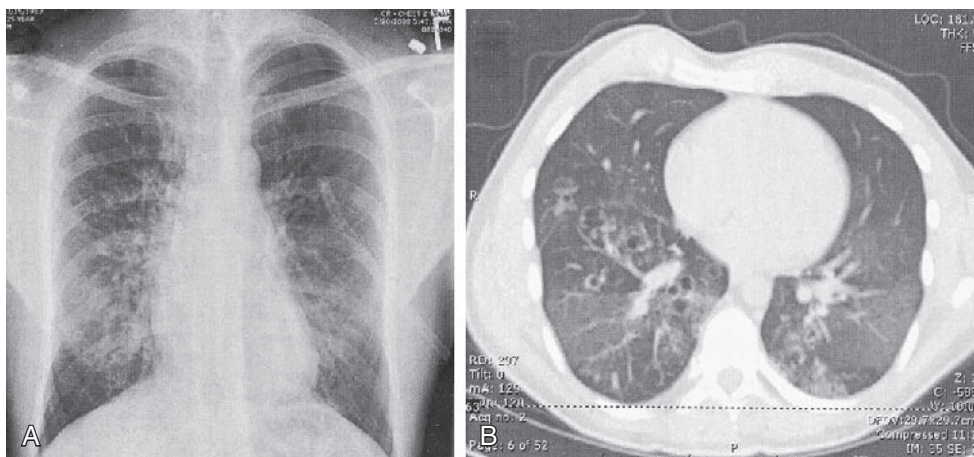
Chest radiograph (A) and chest computed tomographic (CT) scan (B) of a patient with severe bronchiectasis. The abnormally dilated airways are better appreciated on the CT scan.
